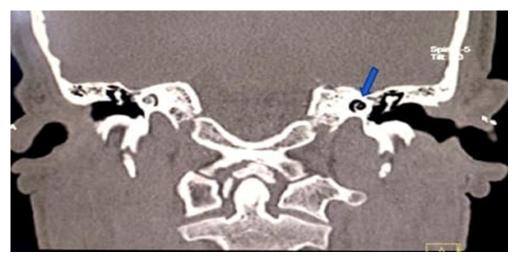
Inframillimetric CT image of the temporal bone in coronal section showing a pneumocochlea in the left ear (blue arrow), contrasting with a normal appearance of the cochlea in the right ear.
